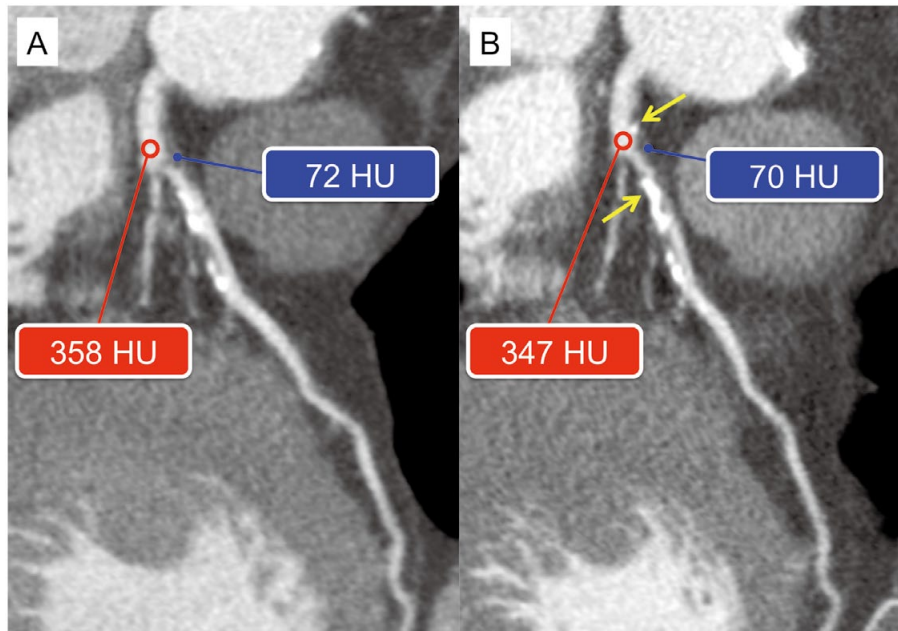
Follow-up using the diluted contrast material (CM) protocol. Curved multiplanar reformatted images at the left main trunk and left anterior descending coronary artery (window level/width: 90/750). A 75-year-old woman with suspected coronary artery disease underwent (A) coronary computed tomography angiography (body weight, 63 kg; iodine dose, 11.4 g iodine; dilution rate, 65%) and (B) a follow-up scan after 30 months of lipid-lowering therapy (body weight, 75 kg; iodine dose, 14.0 g iodine; dilution rate, 80%) using the same diluted CM protocol. (A) and (B) had almost equivalent coronary attenuations (red circles and lines). Coronary stenosis and the adjacent plaque attenuation were able to be evaluated (blue points and lines), which had not changed significantly. Some non-calcified plaques became calcified (yellow arrows).
